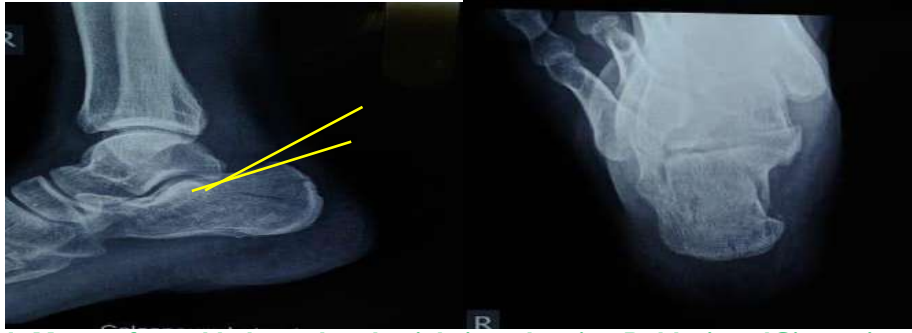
X-ray of rt ankle lateral and axial view showing Bohler's and Gissane's angle
